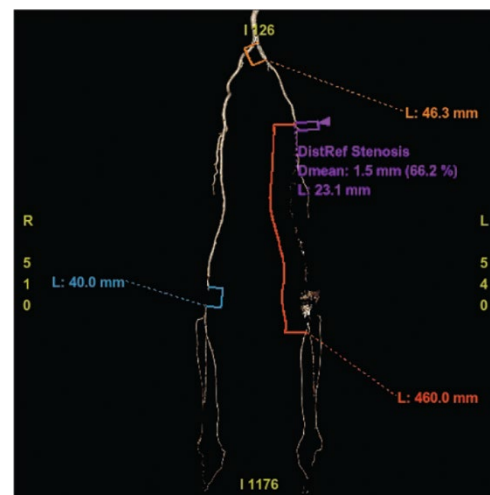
Computed tomography of the arteries of the lower extremities
